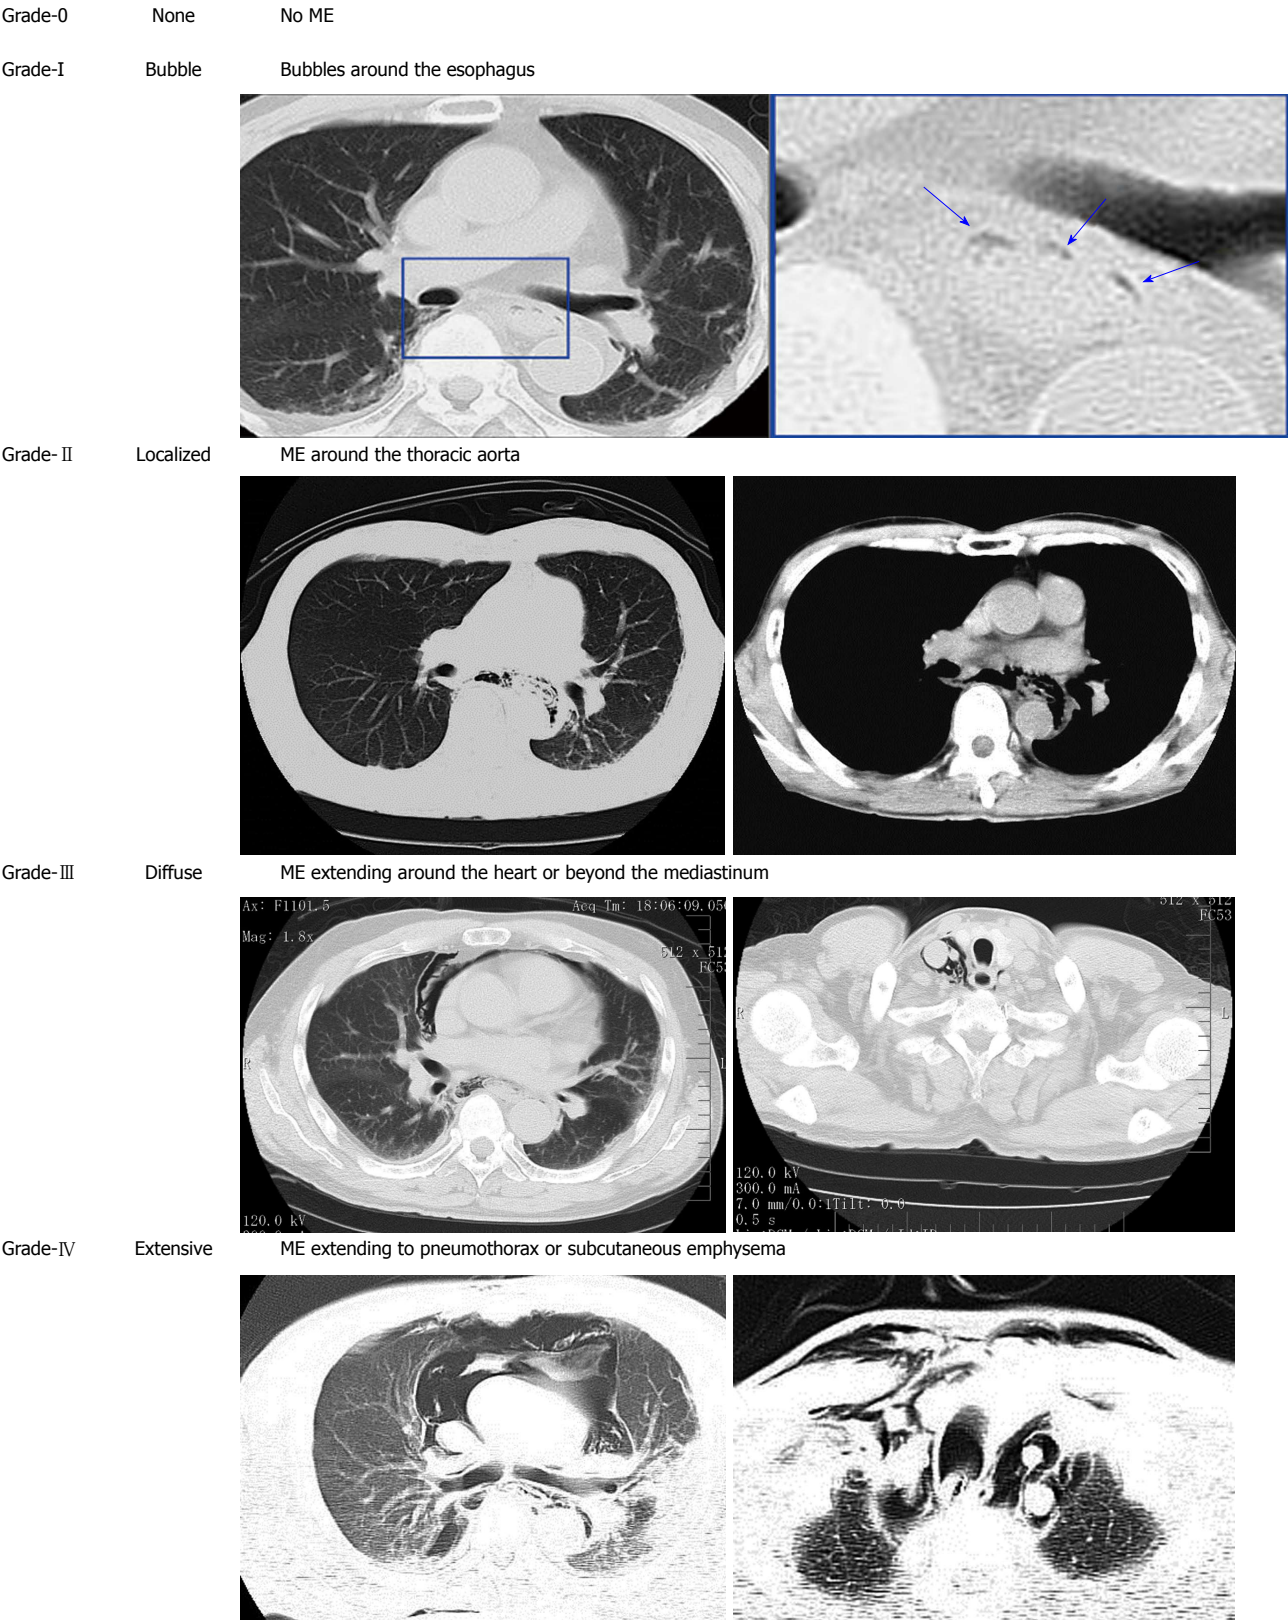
Grade of mediastinal emphysema on computed tomography^[9].
